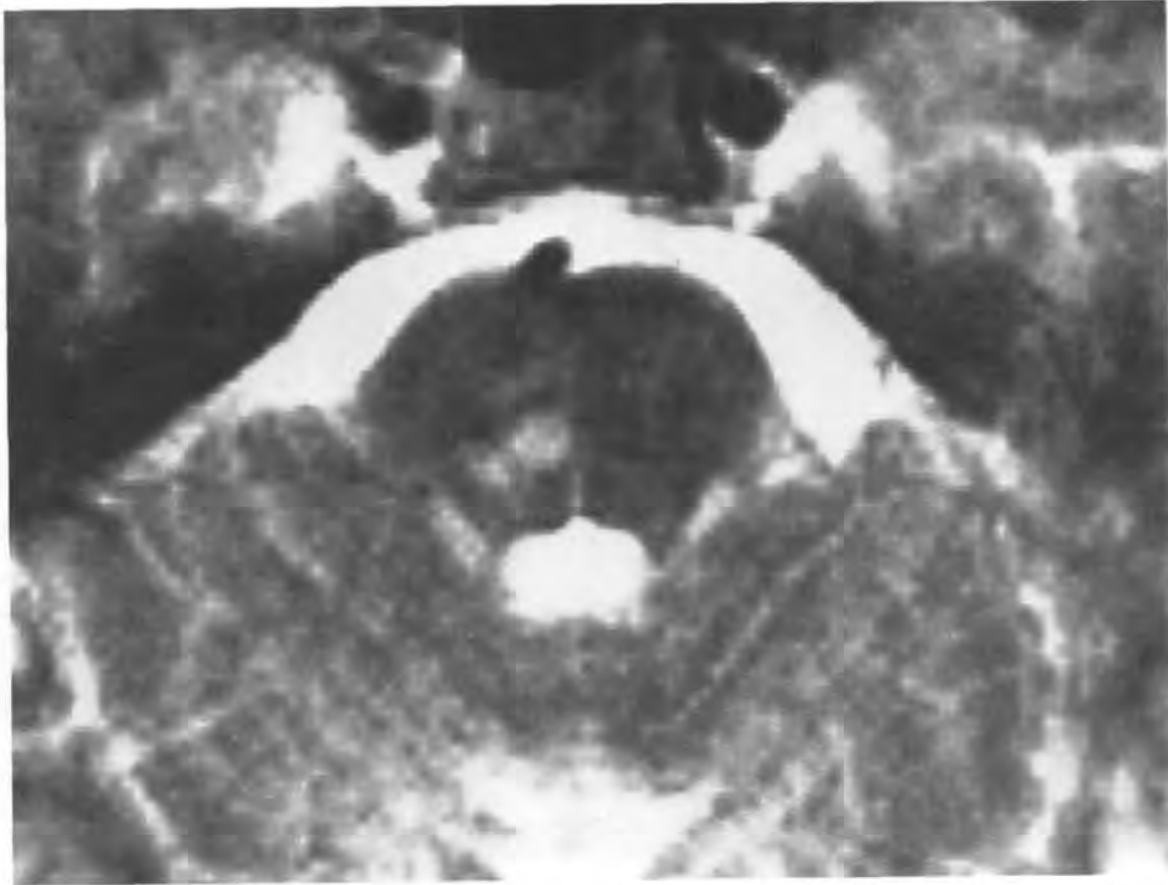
Axial T2-weighted magnetic resonance image showing hyperintense signal in right paramedial tegmentum of pons in 53-year-old hypertensive man with pure sensory stroke.
